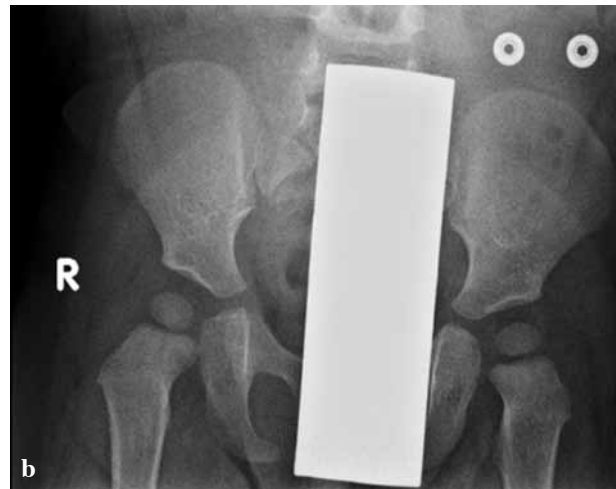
Radiograph of the left knee and the pelvis (left hip) after 20 months.
